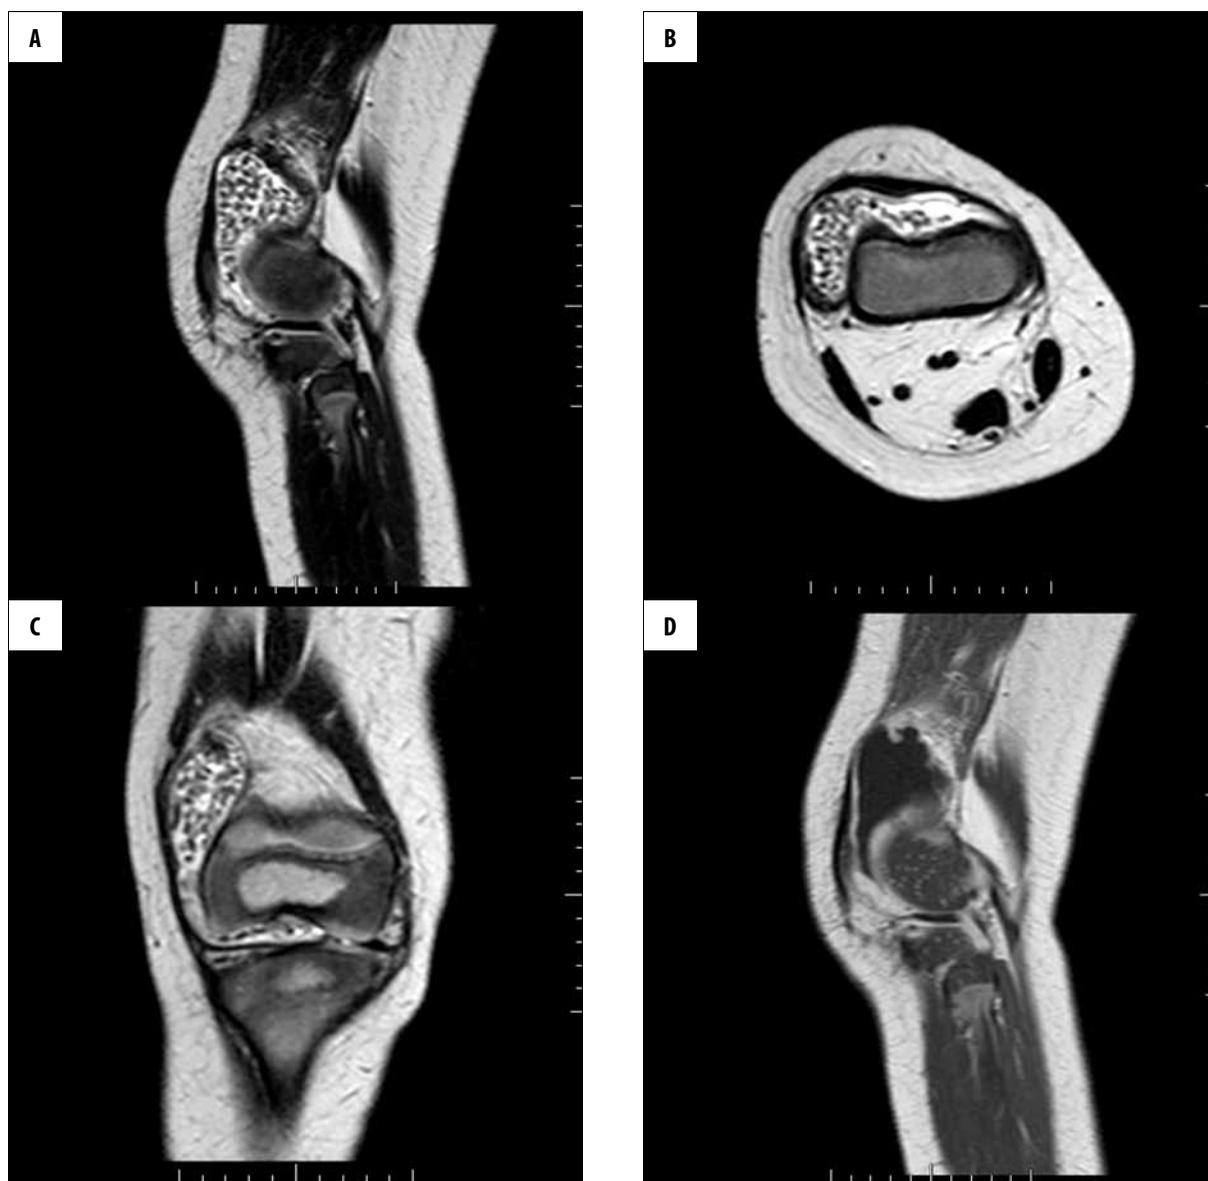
MRI of the knee. T2-weighted images. (A) Sagittal plane. (B) Transverse plane. (C) Frontal plane. Numerous small foci devoid of signal – loose chondral bodies within joint cavity, located mainly in the suprapatellar bursa as well as medial and lateral patellofemoral recesses. (D) T1-weighted + CM image, sagittal plane. Contrast enhancement of thickened synovial membrane.
